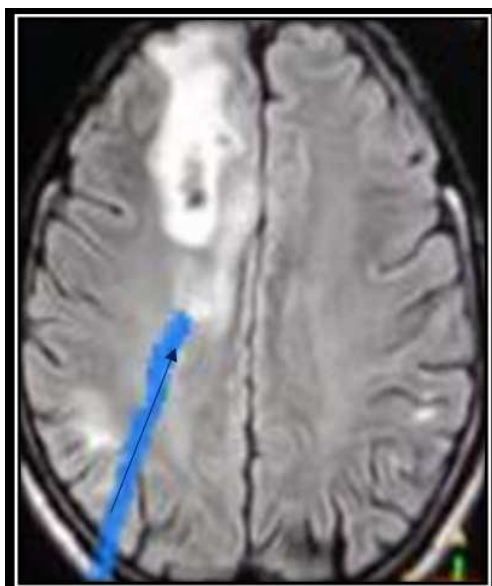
Iso-Hypointense foci in white matter (marked blue arrow) with surrounding oedema suggestive of metastasis seen on T2 contrast of Magnetic Resonance Imaging involving brain.
